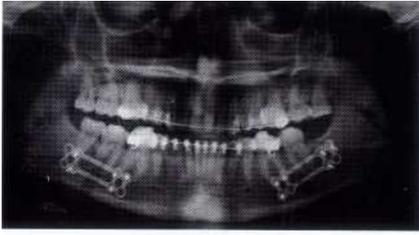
Radiograph showing titanium internal fixation hardware for the sagittal osteotomy.
